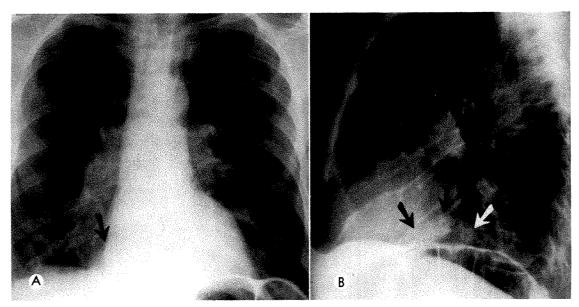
Case III. (A) Posteroanterior and (B) lateral chest roentgenograms reveal infiltration and pleural reaction at base of right lung, and a soft tissue mass in the right cardiophrenic angle (arrows).
